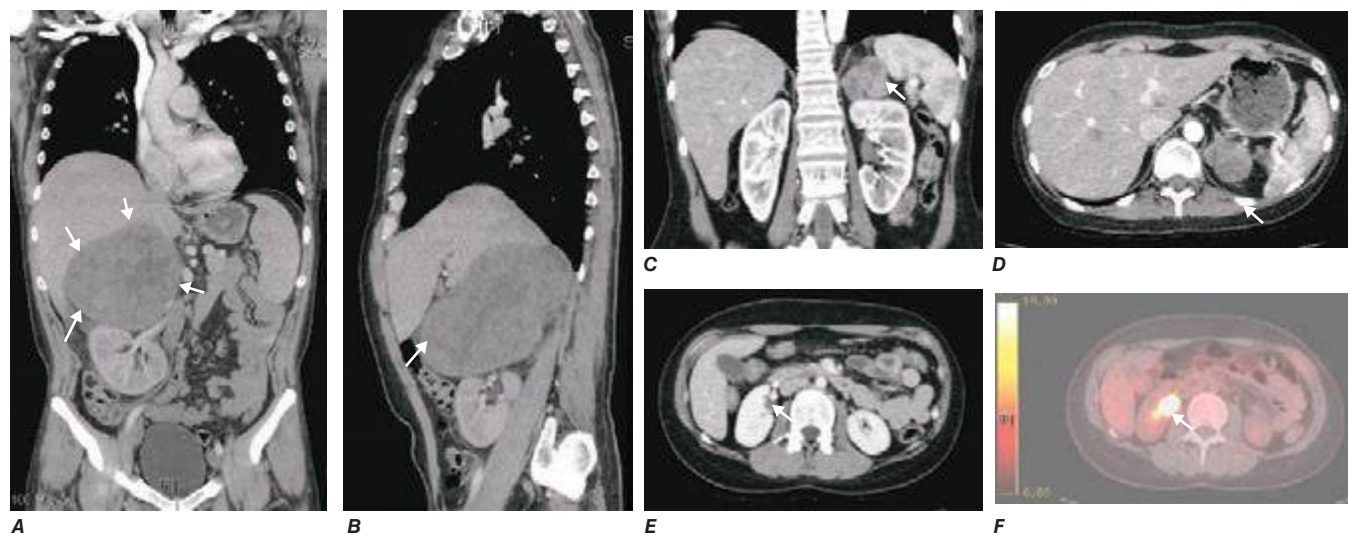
Imaging in adrenocortical carcinoma. Magnetic resonance imaging scan with (A) frontal and (B) lateral views of a right adrenocortical carcinoma that was detected incidentally. Computed tomography (CT) scan with (C) coronal and (D) transverse views depicting a right-sided adrenocortical carcinoma. Note the irregular border and inhomogeneous structure. CT scan (E) and positron emission tomography/CT (F) visualizing a peritoneal metastasis of an adrenocortical carcinoma in close proximity to the right kidney (arrow).
